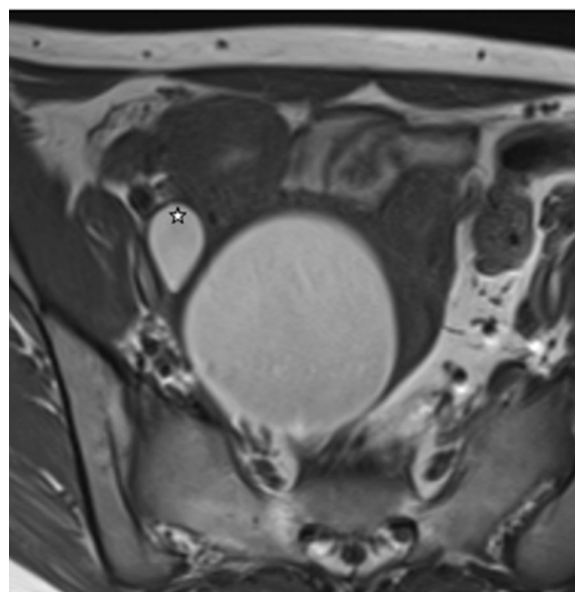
MRI pelvis T1 axial images. A T1 hyperintense cystic structure (star) in the right adnexa inserting into the upper vagina—likely a blind right ectopic ureter with hematic reflux from hematocolpos
